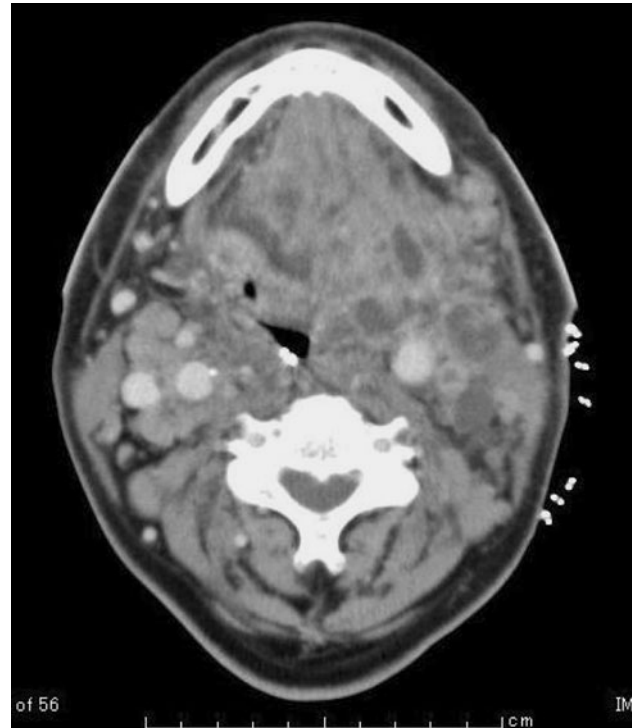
Patient 2: axial view of the CT image at the level of supraglottis 3 h before the episode of CPA. The tumor and bilateral enlarged cervical lymphatic masses occupy almost the whole oral cavity and displace the trachea to the right
